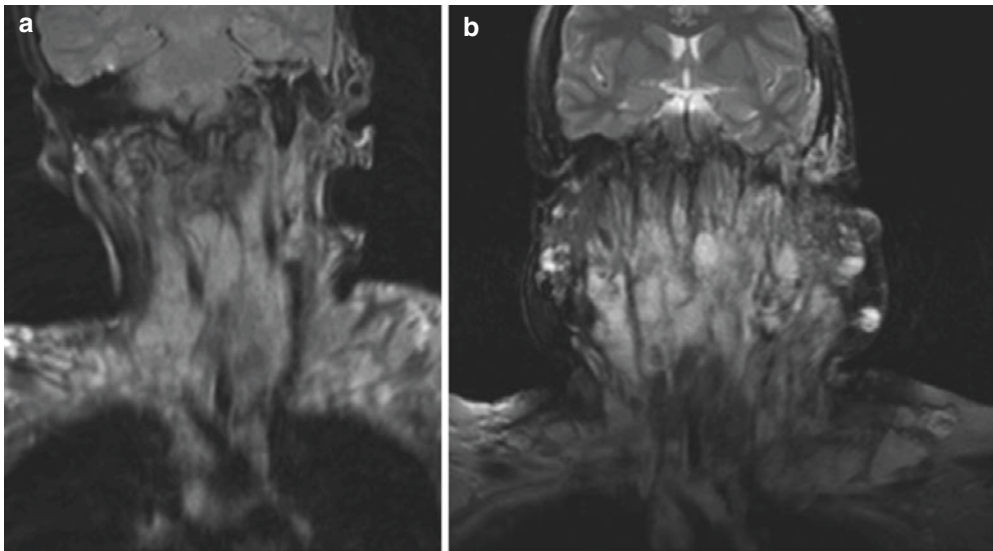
Diffuse VM of the neck, face, airway, scalp, thoracic inlet, and shoulder, presenting with airway obstruction at 4 years of age. VM grew aggressively over childhood and early adulthood. Patient did not do well on rapamycin due to poor compliance. This case shows the need for biological treatment. (a) Coronal T2-weighted image at 4 years of age showing the extensive VM.
